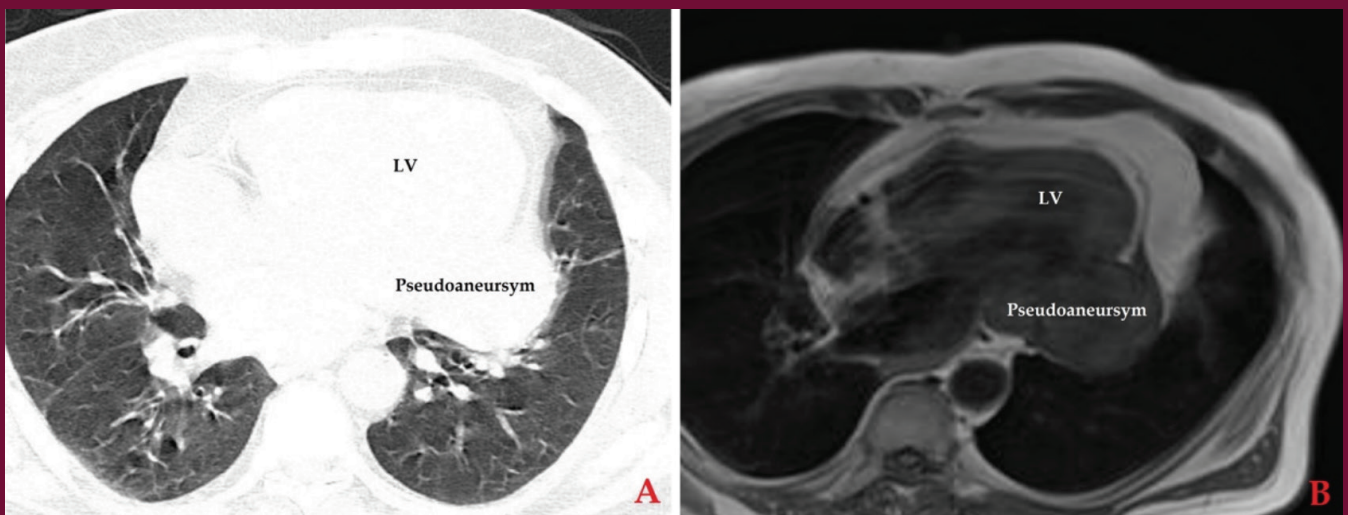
A) Computed tomography scan showing a mass on the LV, B) Cardiac MRI showing pseudoaneurysm on the posterolateral side of the LV
